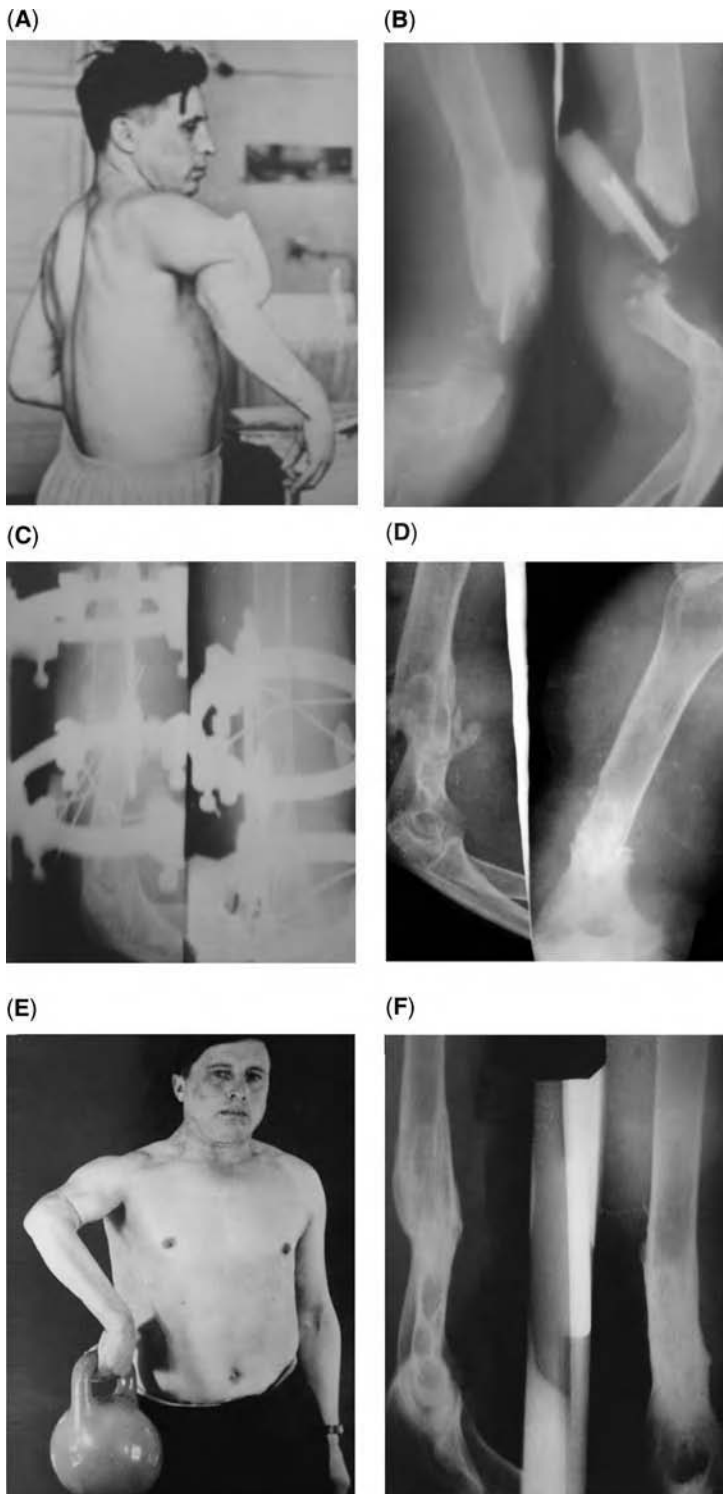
(A) Patient with nonunion of distal third of the right humerus (six years after injury and four unsuccessful surgeries including bilateral tibial bone autografts and plastic endoprosthesis); (B) radiographs before surgery (note a free floating plastic prosthesis from previous surgery); (C) radiographs on the day of the application of the frame under regional anesthesia (April 3, 1964); (D) radiographs on the day of frame removal (total time in the frame: 33 days); (E) patient four years after surgery; (F) radiographs of the right humerus four years after surgery.
